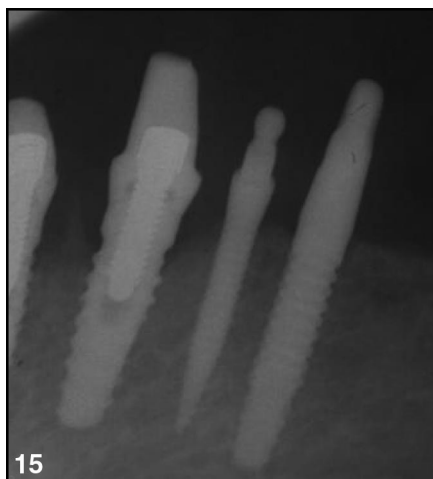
Radiographic bone loss, typical to 4.1 mm standard diameter implants, is evident on the far left implant, and slight radiographic bone loss is seen on the 3 mm diameter implant at the far right, but no apparent bone loss is evident on the 2 mm diameter implant in the middle.
